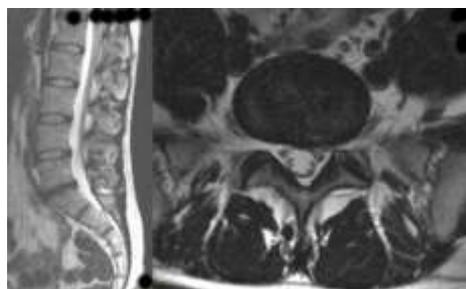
Sagittal and axial T2WI MRI after 4 months showed almost complete regression an extruded disc fragment at the L5-S1 level without nerve root compression.
